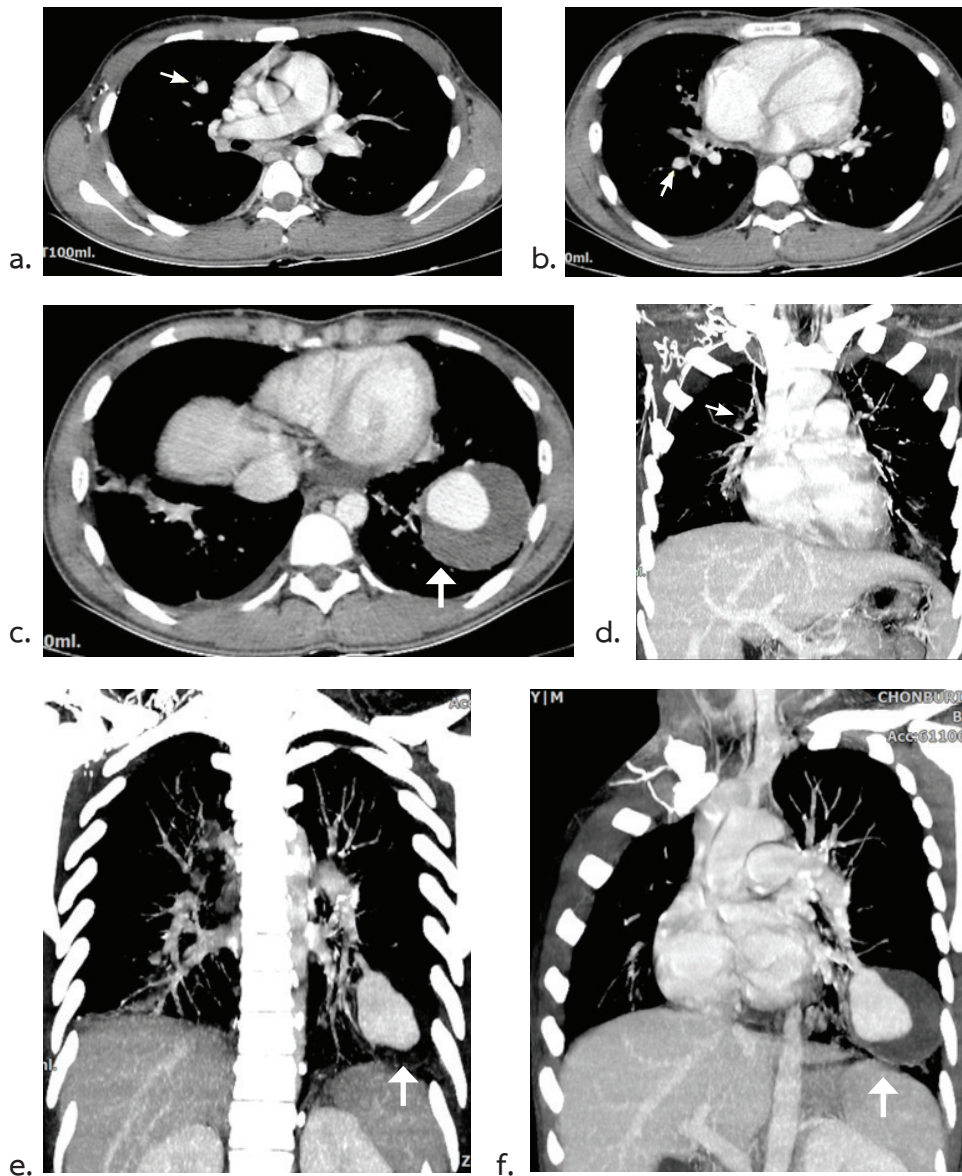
The computed tomography of the chest.
